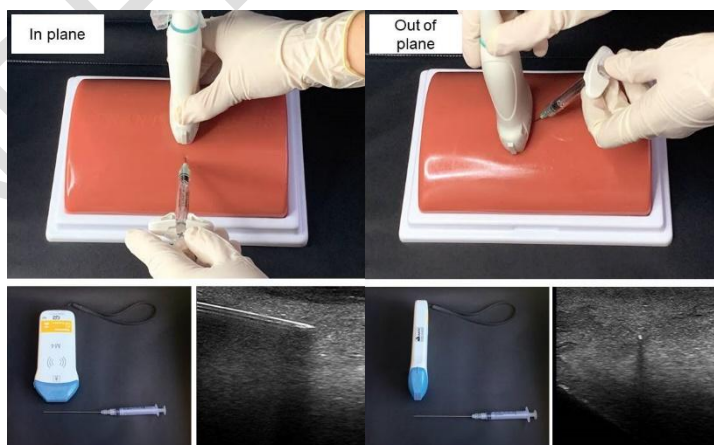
In-plane (Longitudinal plane) or out-of-plane ultrasound technique (Transverse plane) (Kindly provided by Publisher Napoleon Quintessence).
